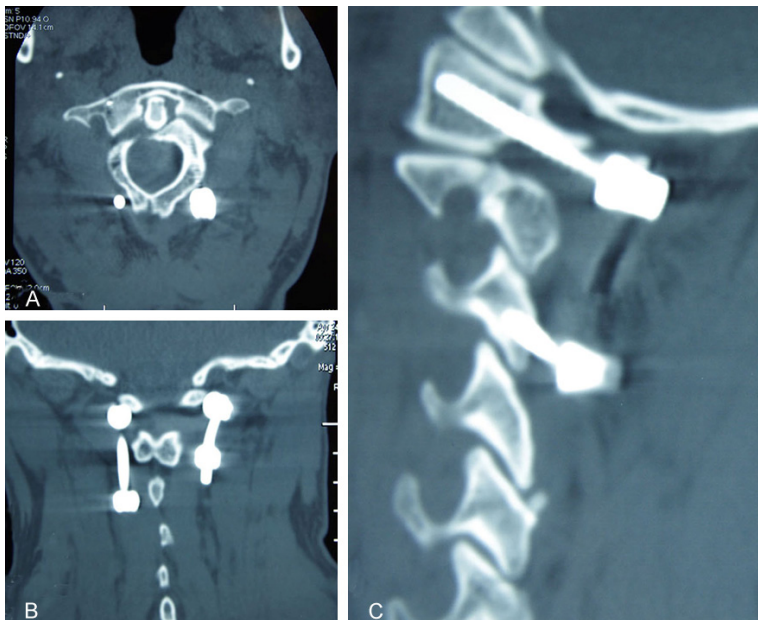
CT scans in axial planes showed that the right C2 pedicle screw was not placed for one patient. The C2 right pedicle of the patient was dysplasia (A), a C3 lateral mass screw was used to replace the C2 pedicle screw for fixation (B, C).
